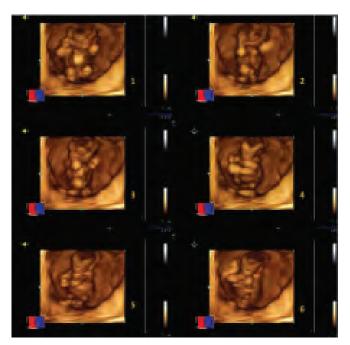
A sequence of images of the fetus at nine weeks of gestation recorded by 4D sonography, showing general movements
